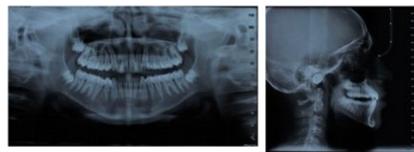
Mid treatment radiographs
